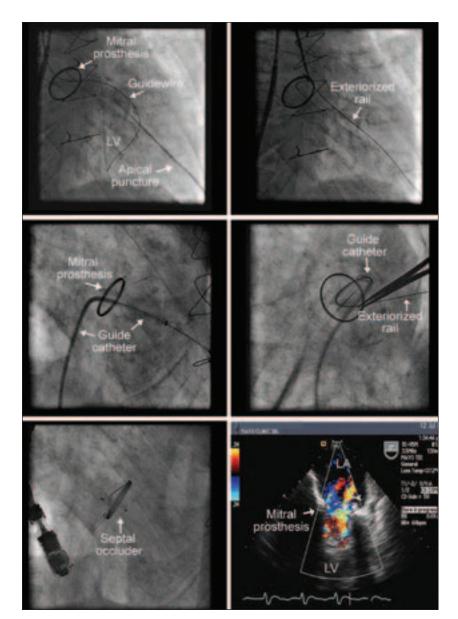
This 74-year-old man underwent percutaneous repair of a perivalvular leak of his St. Jude mechanical mitral prosthesis. Top left, An apical puncture is performed to snare the guidewire, which has been passed across the leak from the left atrium into the left ventricle. Top right, This snaring allows creation of an exteriorized wire rail, which provides strong support for placing devices across the perivalvular leak. Middle left and right, The guide catheter is advanced through the leak over the rail. Bottom left, A septal occluder is deployed across the leak. Bottom right, Transesophageal echocardiography shows occlusion of the leak with only mild central regurgitation through the septal occluder. This central regurgitation resolves with subsequent endothelialization of the septal occluder. LA, left atrium; LV, left ventricle.
